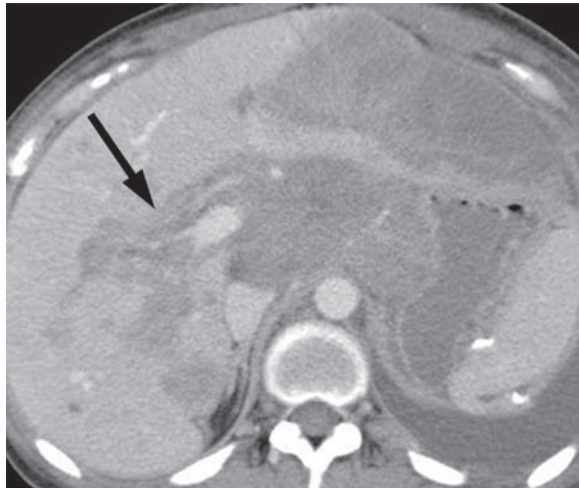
Periportal infiltration by lymphoma in a 24-year-old woman. Contrast-enhanced CT scan shows a homogeneous soft-tissue mass with a slightly expanded contour (arrow) along the right portal vein. Invasion of the hepatic subcapsular region is via the Glisson sheath. A conglomeration of lymph nodes is seen around the celiac axis.
